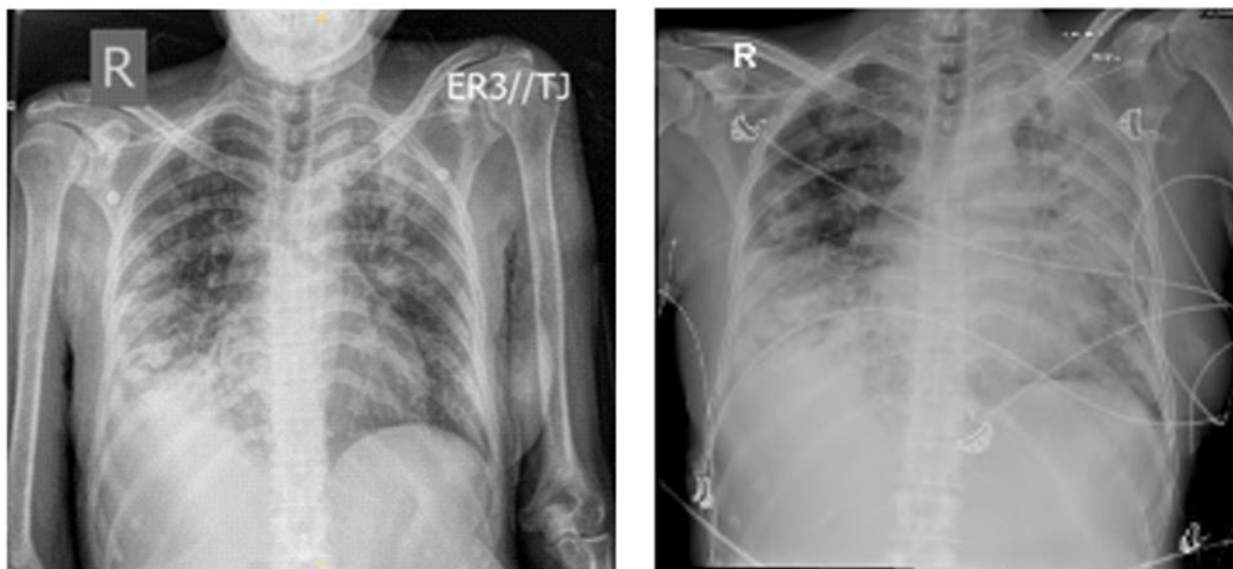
(b) - Chest X-Ray - Patchy opacities in the right mid -lower zones and upper zone and small right pleural effusion suggestive of Pulmonary Tuberculosis Fig. 2(c) - Chest X-Ray -diffuse patchy cavitory consolidation of both lungs due to acute Pulmonary tuberculosis
